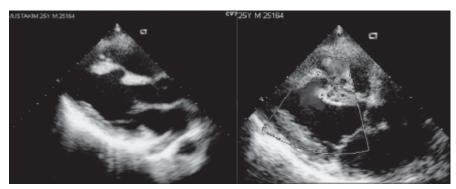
Parasternal long axis view showing dissection of muscular septum (2-D image -left) and CFM (colour flow mapping) showing left to right shunt across VSD (right).
